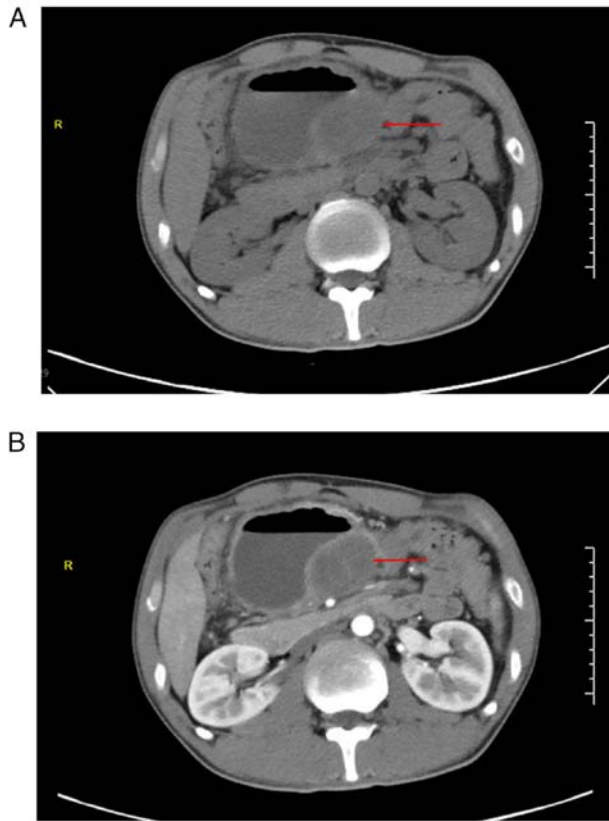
Preoperative imaging examination of patients. (A) Abdominal plain CT. The red arrow indicates an intra-abdominal tumor (~4.8x5.7 cm) surrounded by a dilated intestinal canal and a liquid-gas interface. (B) Abdominal contrast-enhanced CT. The red arrow indicates an intraperitoneal mass. The solid lesion showed mild-to-moderate enhancement with fairly clear margins. CT, computed tomography.
